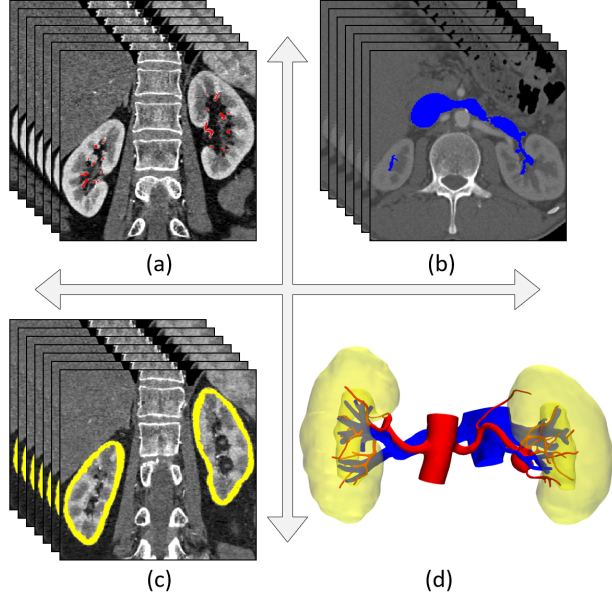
(a) 2D CT images of the renal artery marked in red. (b) 2D CT images of the renal vein marked in blue. (c) 2D CT images of the kidney tissue marked in yellow. (d) Reconstructed 3D renal artery, the renal vein and the kidney tissue colored in red, blue and yellow, respectively.
